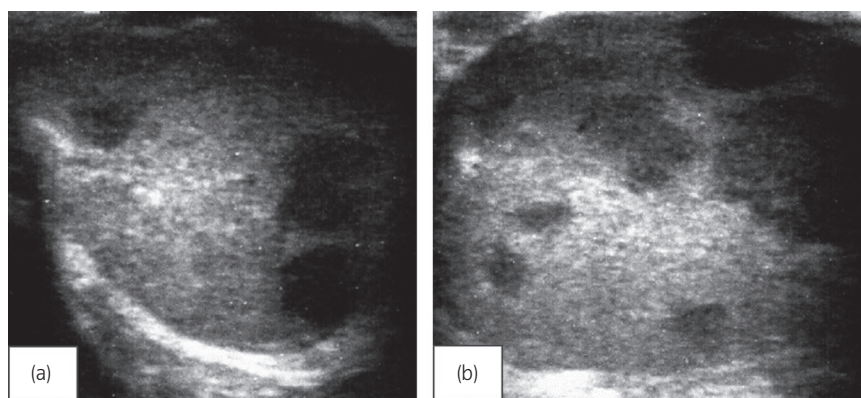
Scrotal ultrasonography. Ultrasonography shows a scattered hypoechoic mass lesions in both testes (a, left testis; b, right testis).
